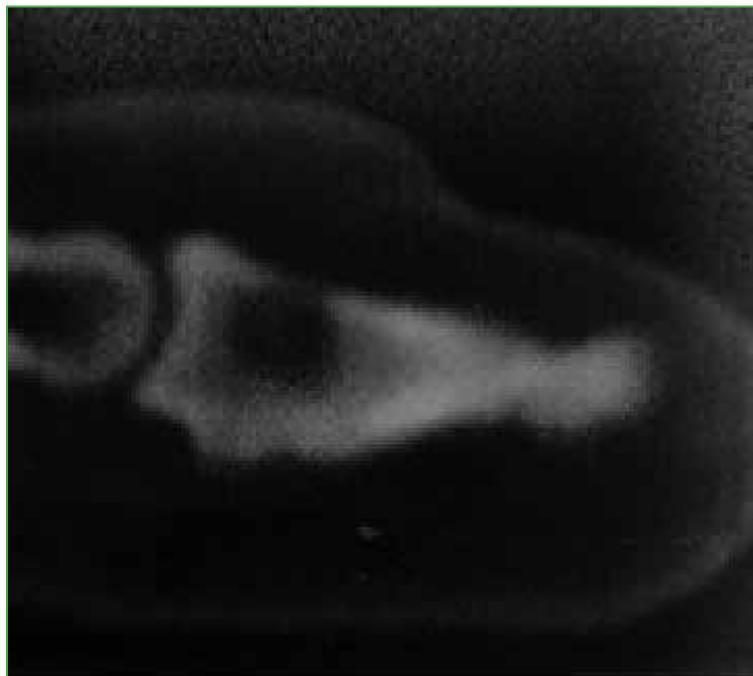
Case 1. CT sagittal section. Osteolytic image evidencing dorsal cortical involvement. Notice the lack of central calcification and reactive sclerosis.
